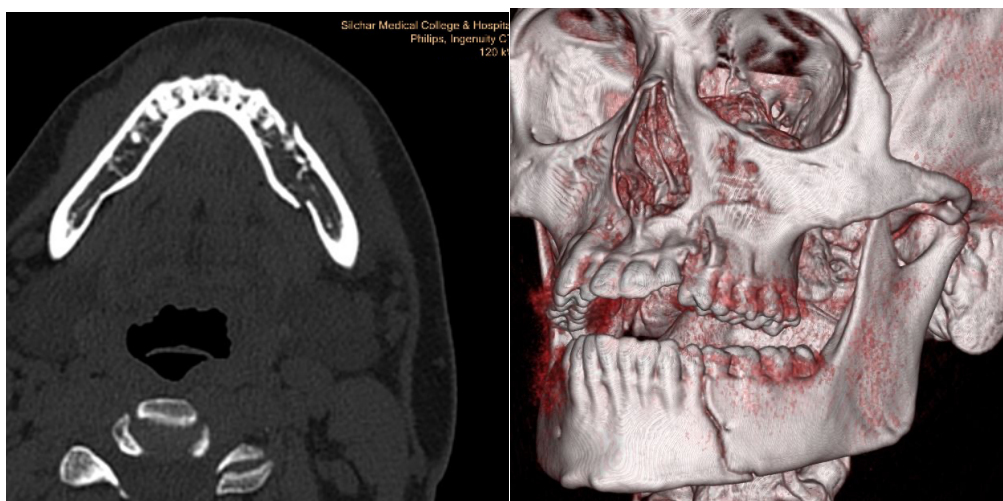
(a) Axial CT image in the patient showing displaced fracture of the body of left hemi mandible with surrounding soft tissue swelling. (b) 3D VR image shows a linear displaced fracture in the left hemi mandible with its extent superiorly up to the alveolar ridge and inferiorly up to the base of the mandible.
